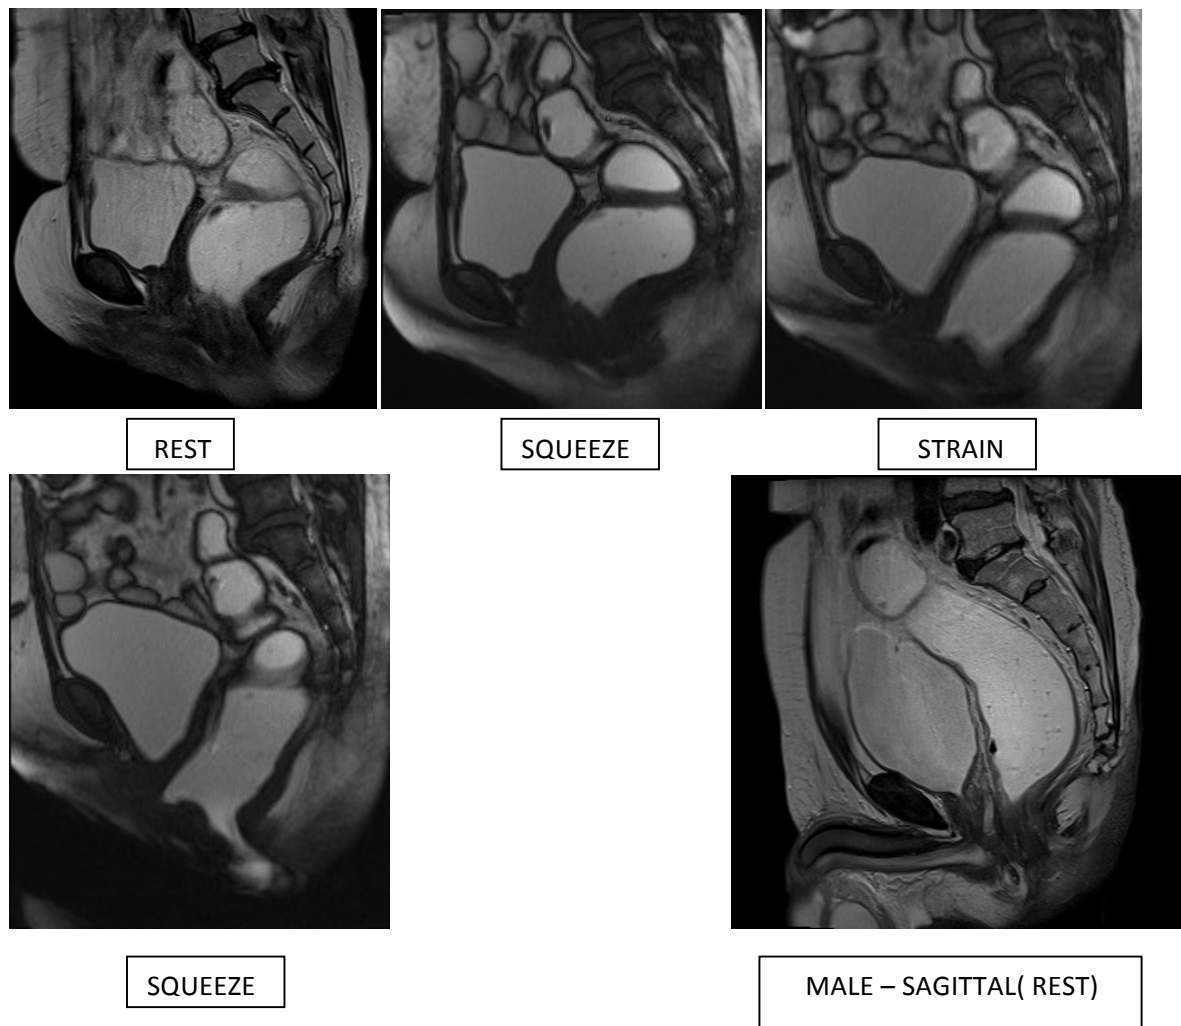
Dynamic phases on MRI
